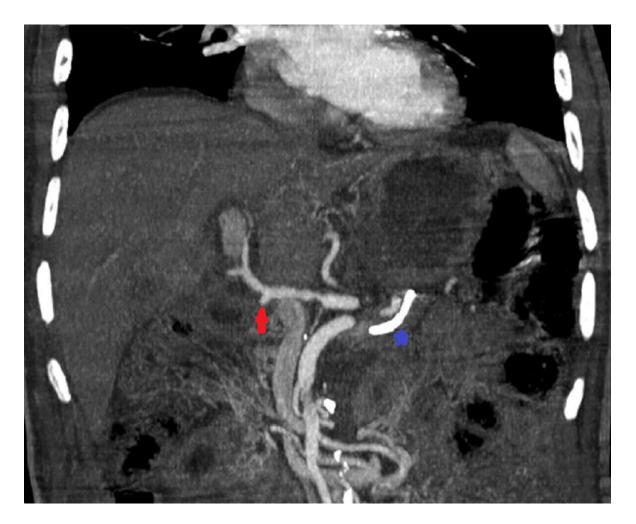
Abdominal and pelvic CT scan injected at the arterial phase showing the stump of the gastro duodenal artery without any anomaly (red arrow) postoperatively. Note the presence of a clip (blue stor)
